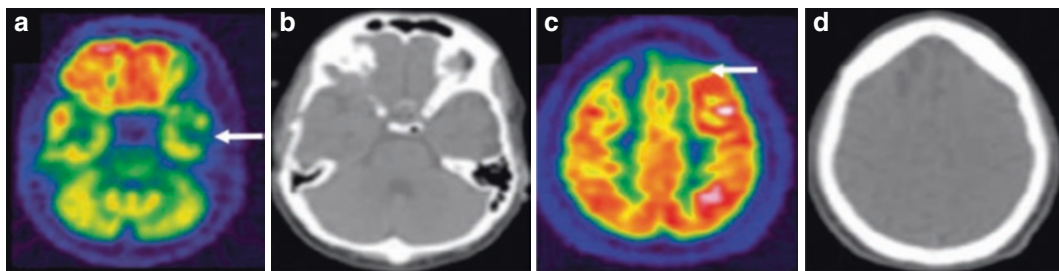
^{18}F -FDG PET/CT images of patients with TBIs. A 25-year-old male patient with a moderate TBI who underwent an ^{18}F -FDG PET/CT scan 5 months after his initial injury: transverse ^{18}F -FDG PET shows decreased metabolism of the left temporal lobe (a, arrow), accompanied by mild brain volume reduction and cerebral
